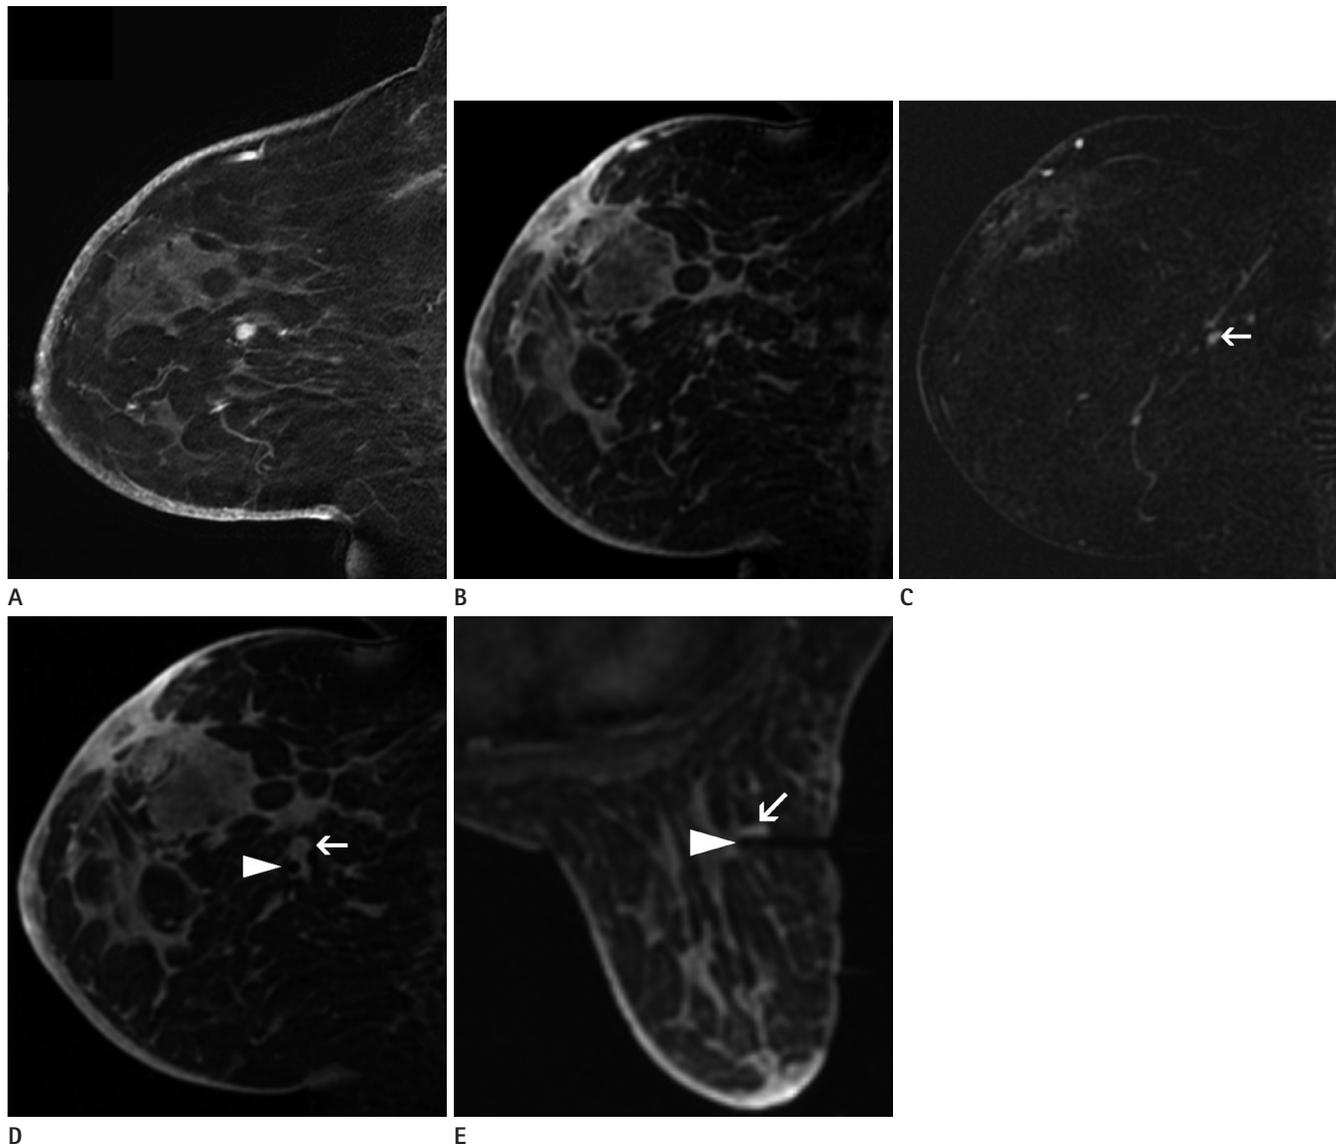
A 35-year-old woman with ipsilateral breast cancer surgery 9 months previously. Postoperative MRI shows a new, round, fast and washout-enhancing mass (A). The patient underwent MRI-guided biopsy. The target lesion is not identified on the postcontrast sagittal image (B). On the subtraction image (C), a subtle enhancing mass is well-delineated (arrow). Repeat MRI (D, E) shows introducer sheath with obturator (arrowhead) in correct position, with the tip at the target lesion (arrow). The enhancing mass was pathologically confirmed as reactive hyperplasia in intramammary lymph node.
